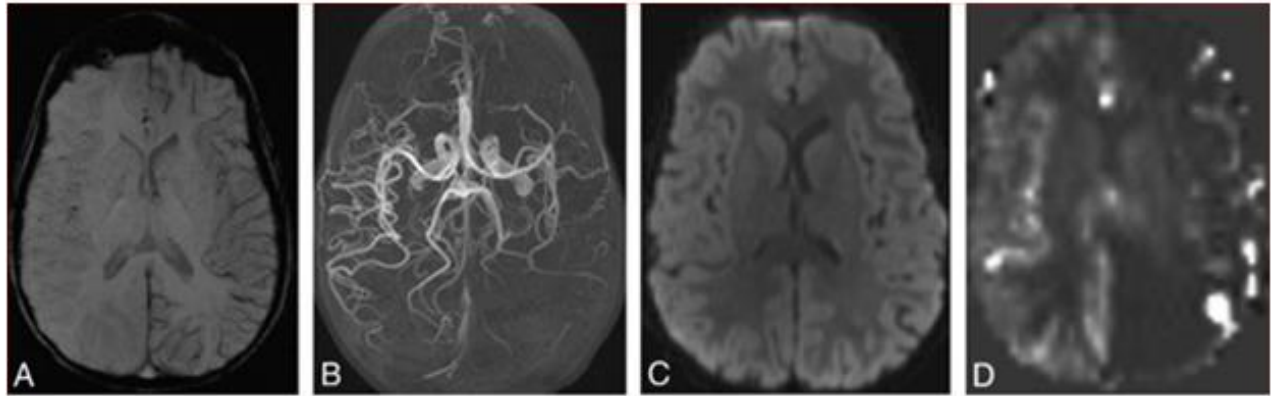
The main pathways of SARS-CoV-2 neuroinvasion and potential mechanisms causing neurological damage. A) The initial MR imaging conducted after admission. A) The susceptibility-weighted MRI reveals heightened visibility of the cortical veins across the left cerebral hemisphere, indicating an increase in deoxyhemoglobin on the left side. B) A collapsed maximum intensity projection from time-of-flight MR angiography displays reduced flow-related enhancement in the left anterior, middle, and posterior cerebral arteries. C) The diffusion tensor image's average trace exhibits no abnormalities in diffusion. D) The pulsed arterial spin-labeled perfusion-weighted imaging's relative CBF map demonstrates a significant decline in perfusion throughout the left cerebral hemisphere.
